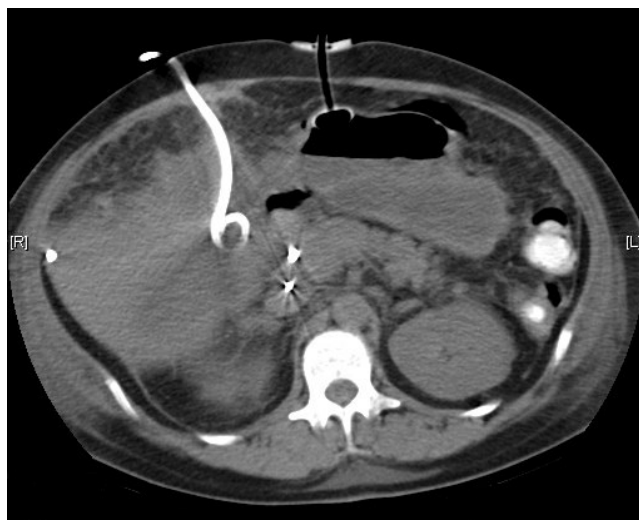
Computed tomographic image showing an example of simultaneous use of a percutaneous pigtail catheter to drain a bile collection (left) and a PEG tube (center) in the same patient.
